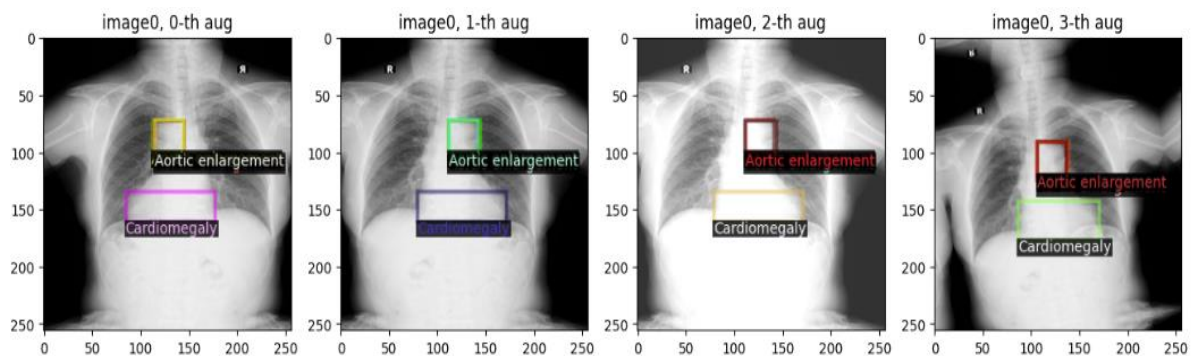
Localizing Thoracic Abnormalities in Chest X-ray Images
